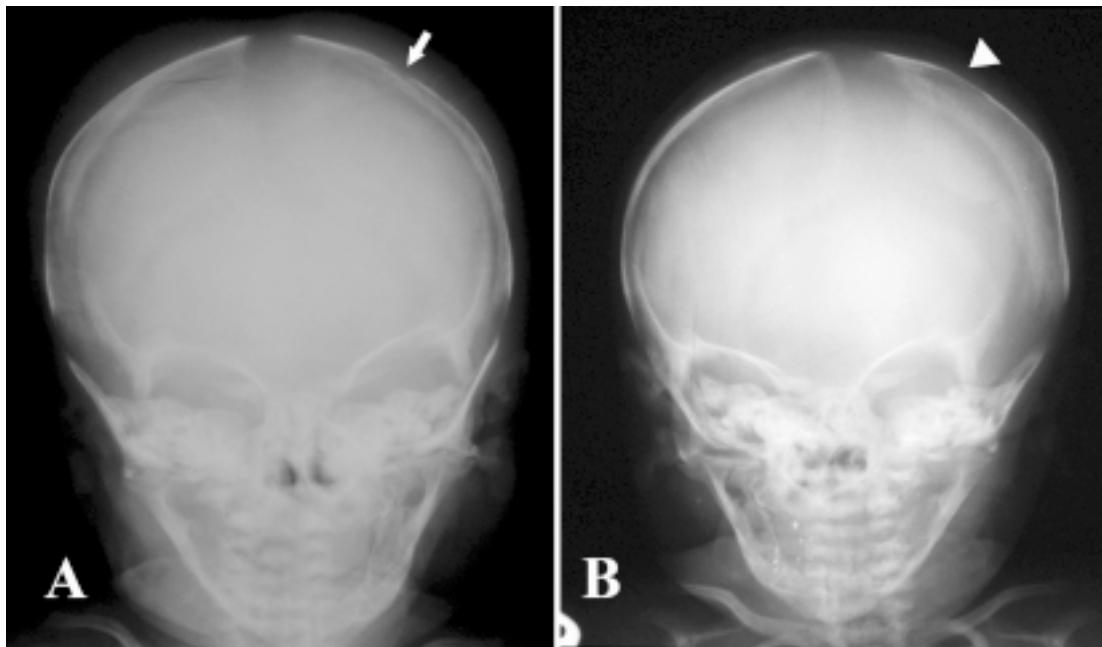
Anteroposterior view of skull radiograph on admission shows a small osteolytic lesion of the left parietal bone (arrow). B) Serial skull radiograph on Day 10 of hospitalization reveals an increase in size of the osteolytic lesion with a sclerotic border (triangle).
